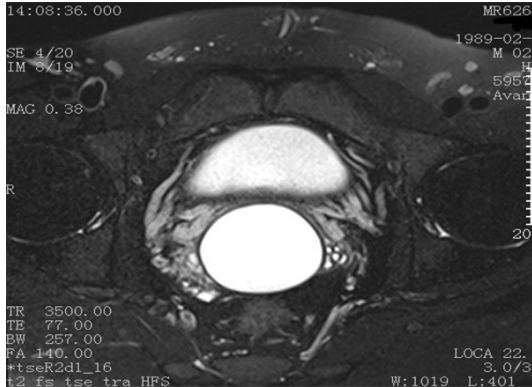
The MRI image of the seminal vesicles (SV) and prostate. There is a 7.0*5.4 cm high signal intensity cyst in the midline region of the prostate on T2 weighted images.
